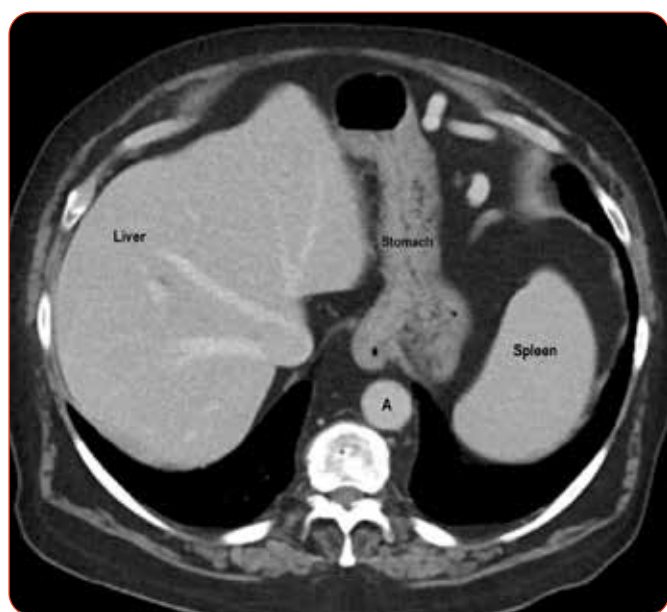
Axial CT image showing liver, stomach, spleen and aorta (A).
